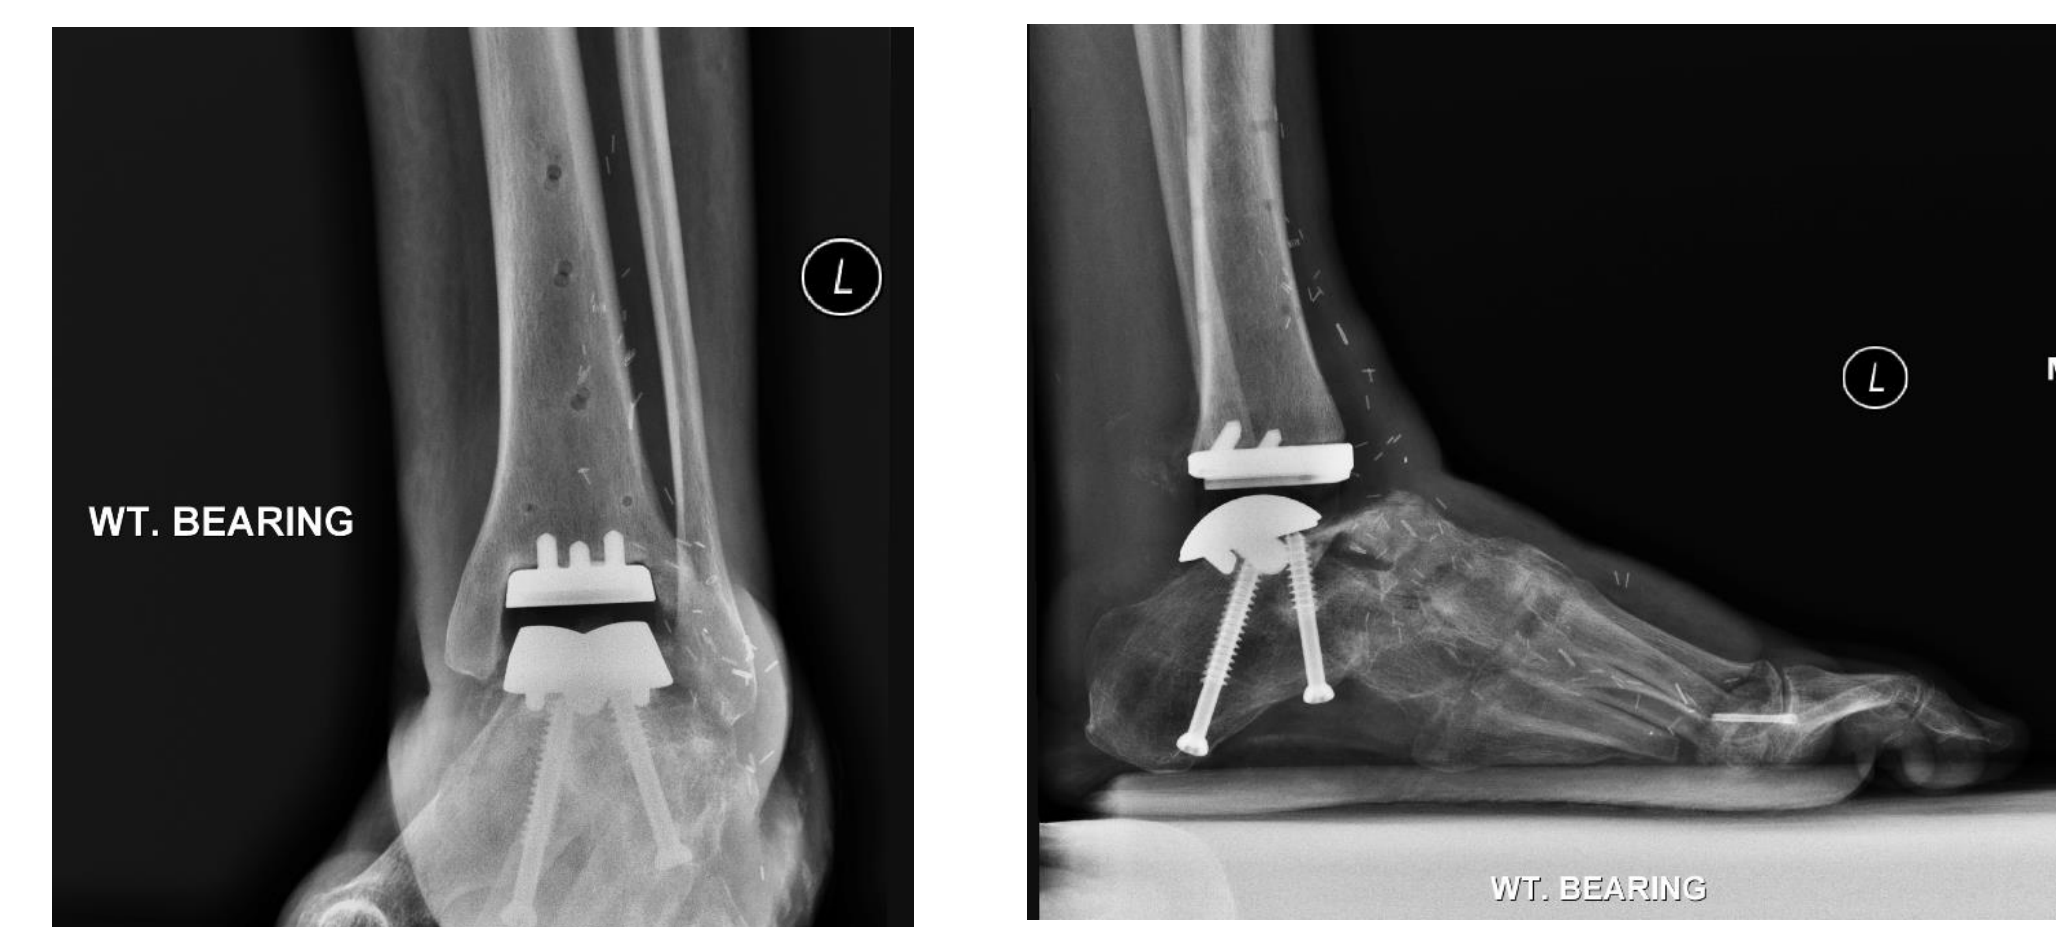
Postoperative weight bearing x-ray films obtained of the left ankle revealing interval placement of ankle implant without signs of hardware failure or loosening
